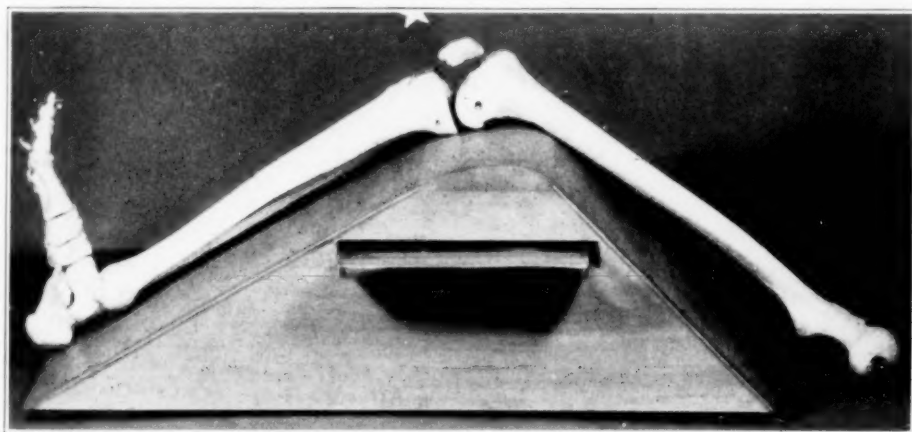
Knee bridge position for x-ray tunnel view.
